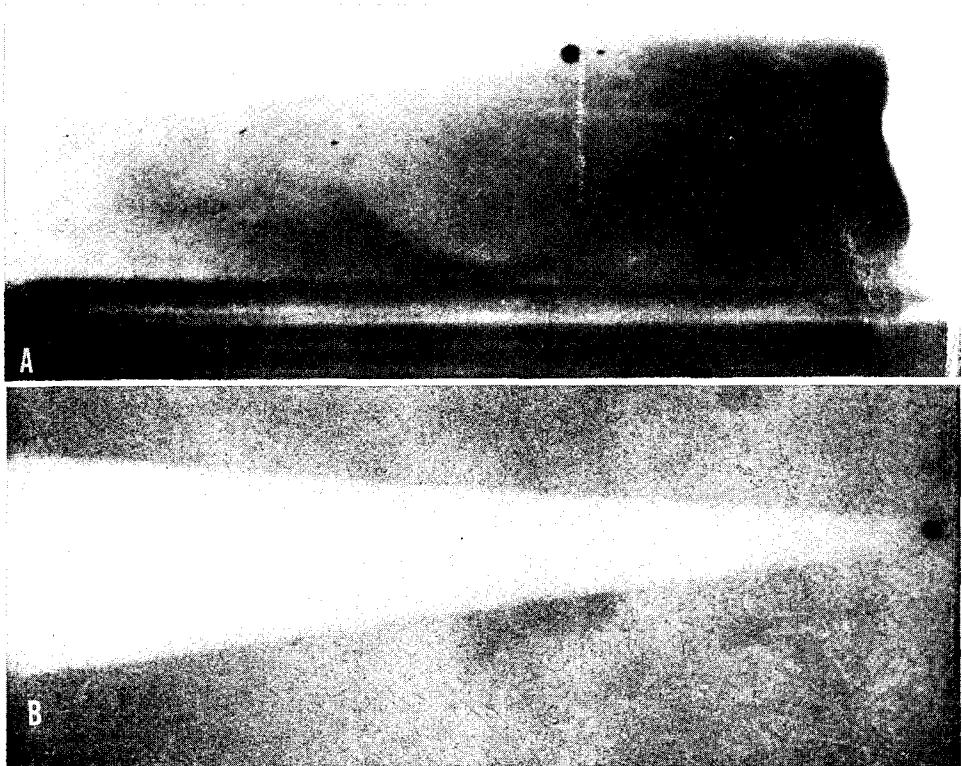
Microsecond roentgenograms. A. Roentgenogram (No. 105) of a $\frac{1}{32}$ -inch steel sphere passing through a block of butcher meat. The sphere struck the meat with a velocity of 2,800 f.p.s. Compare with B and note the similarity of the cone-shaped temporary cavity to that formed in water. B. Roentgenogram (No. 25) of a $\frac{1}{32}$ -inch steel sphere passing into a container of water.
